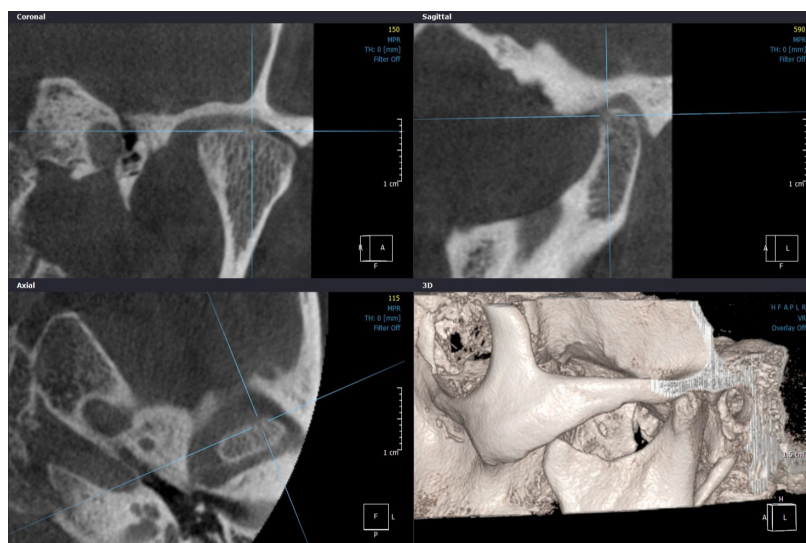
CBCT Corrected Sagittal and Coronal views of the Left TMJ from the same patients shows the area of Erosion.
